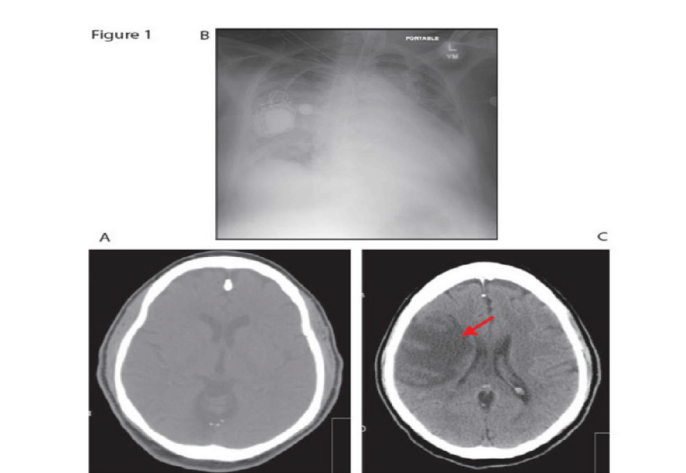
1A. Chest X-ray findings. CXR with increased opacity of both lung fields consistent with pulmonary edema 1B. CT scan of the head Initial CT scan of the head with no acute abnormal finding. 1C. Repeat CT scan of the head with massive acute infarction in the right middle cerebral artery area (red arrow).
